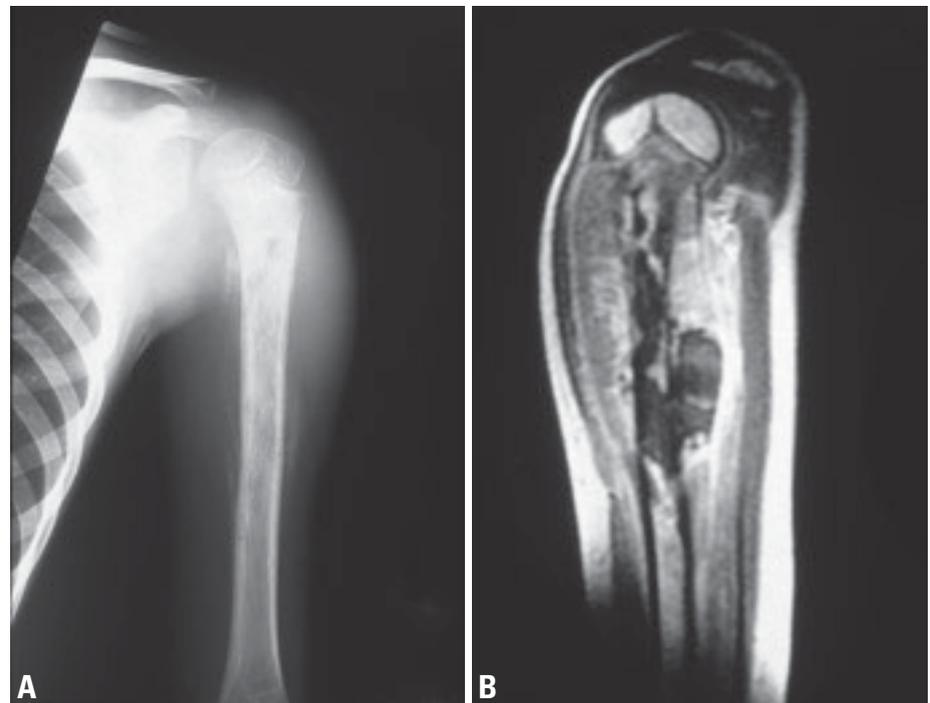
Ewing sarcoma of the left humerus in a 6-year-old boy. A Periosteal new bone formation showing "onion-skin" appearance. B Axial T1-weighted MRI of the same lesion. Both intraosseous and extraosseous tumours are more clearly demonstrated than on plain X-ray.
